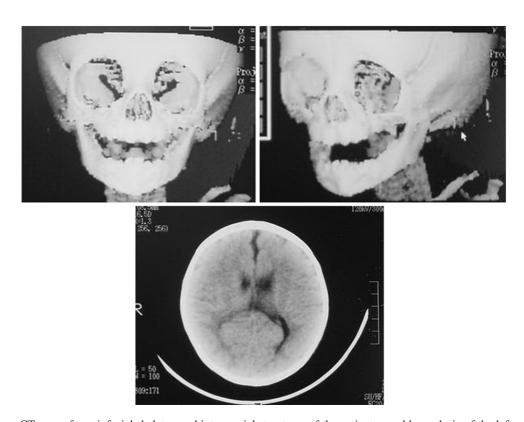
CT scan of craniofacial skeleton and intracranial structures of the patient reveal hypoplasia of the left zygoma, orbit, and mandible diagnosed as craniofacial microsomia, type IIB with no associated intracranial anomalies.
